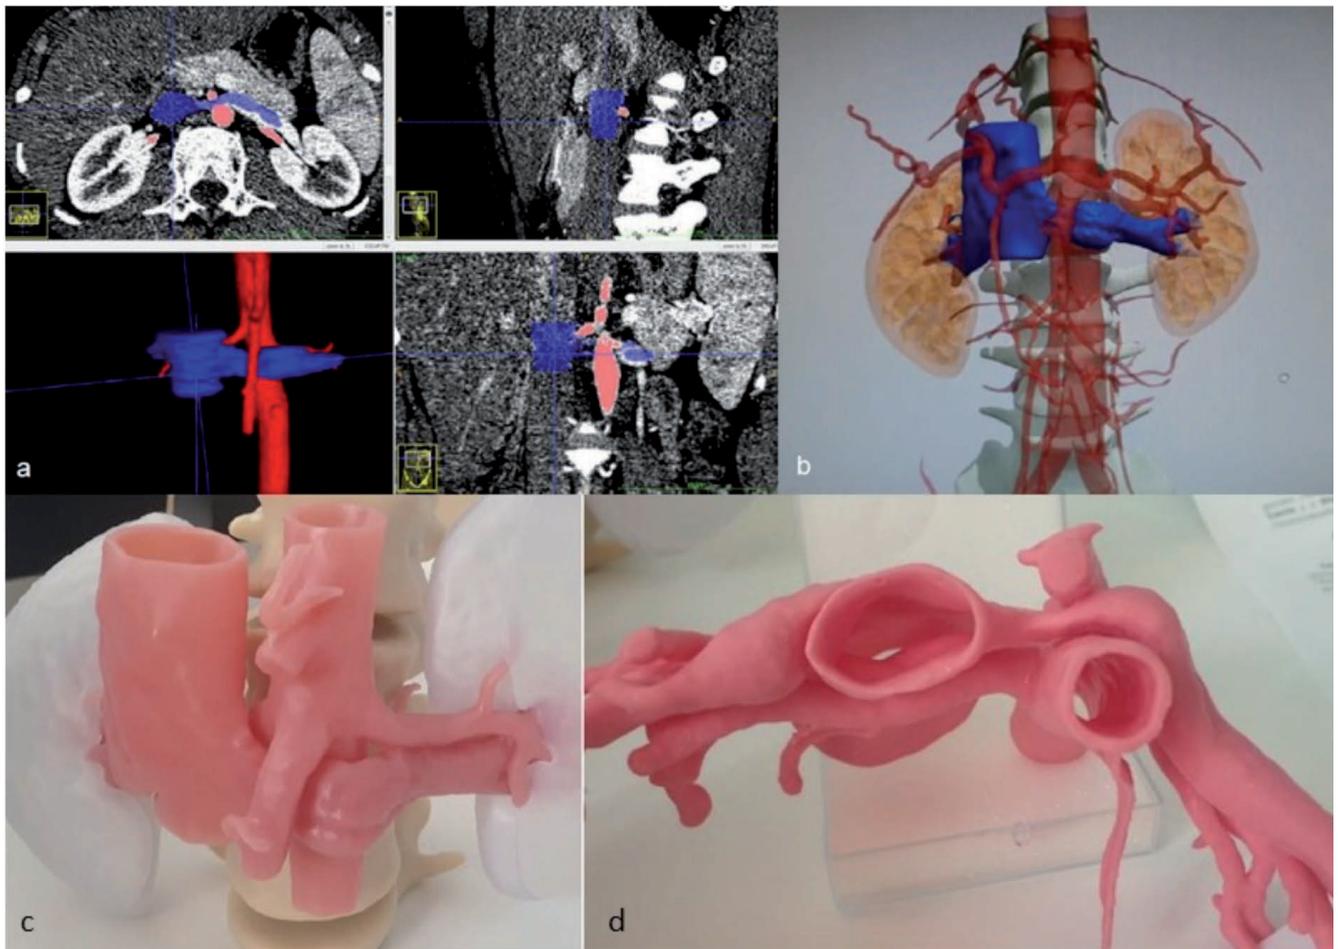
a) CT images (LRV and inferior vena cava in blue, SMA and AA in red); b) 3D model after image conversion; c-d) printed model of the patient's vessels obtained from 3D reconstruction of the CT images.
